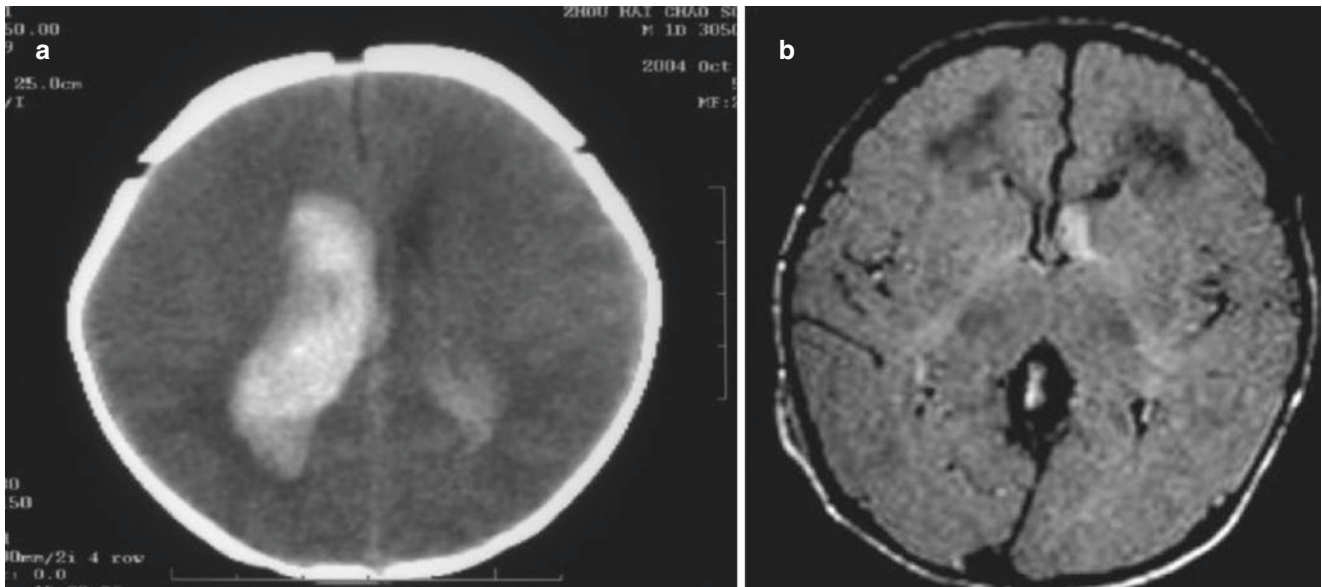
CT and MRI manifestations of neonatal intracranial hemorrhage. (a). CT shows extensive hemorrhage in the right ventricle. (b). MRI (T1WI) shows hyperintense hemorrhage near the anterior horn of the left ventricle
